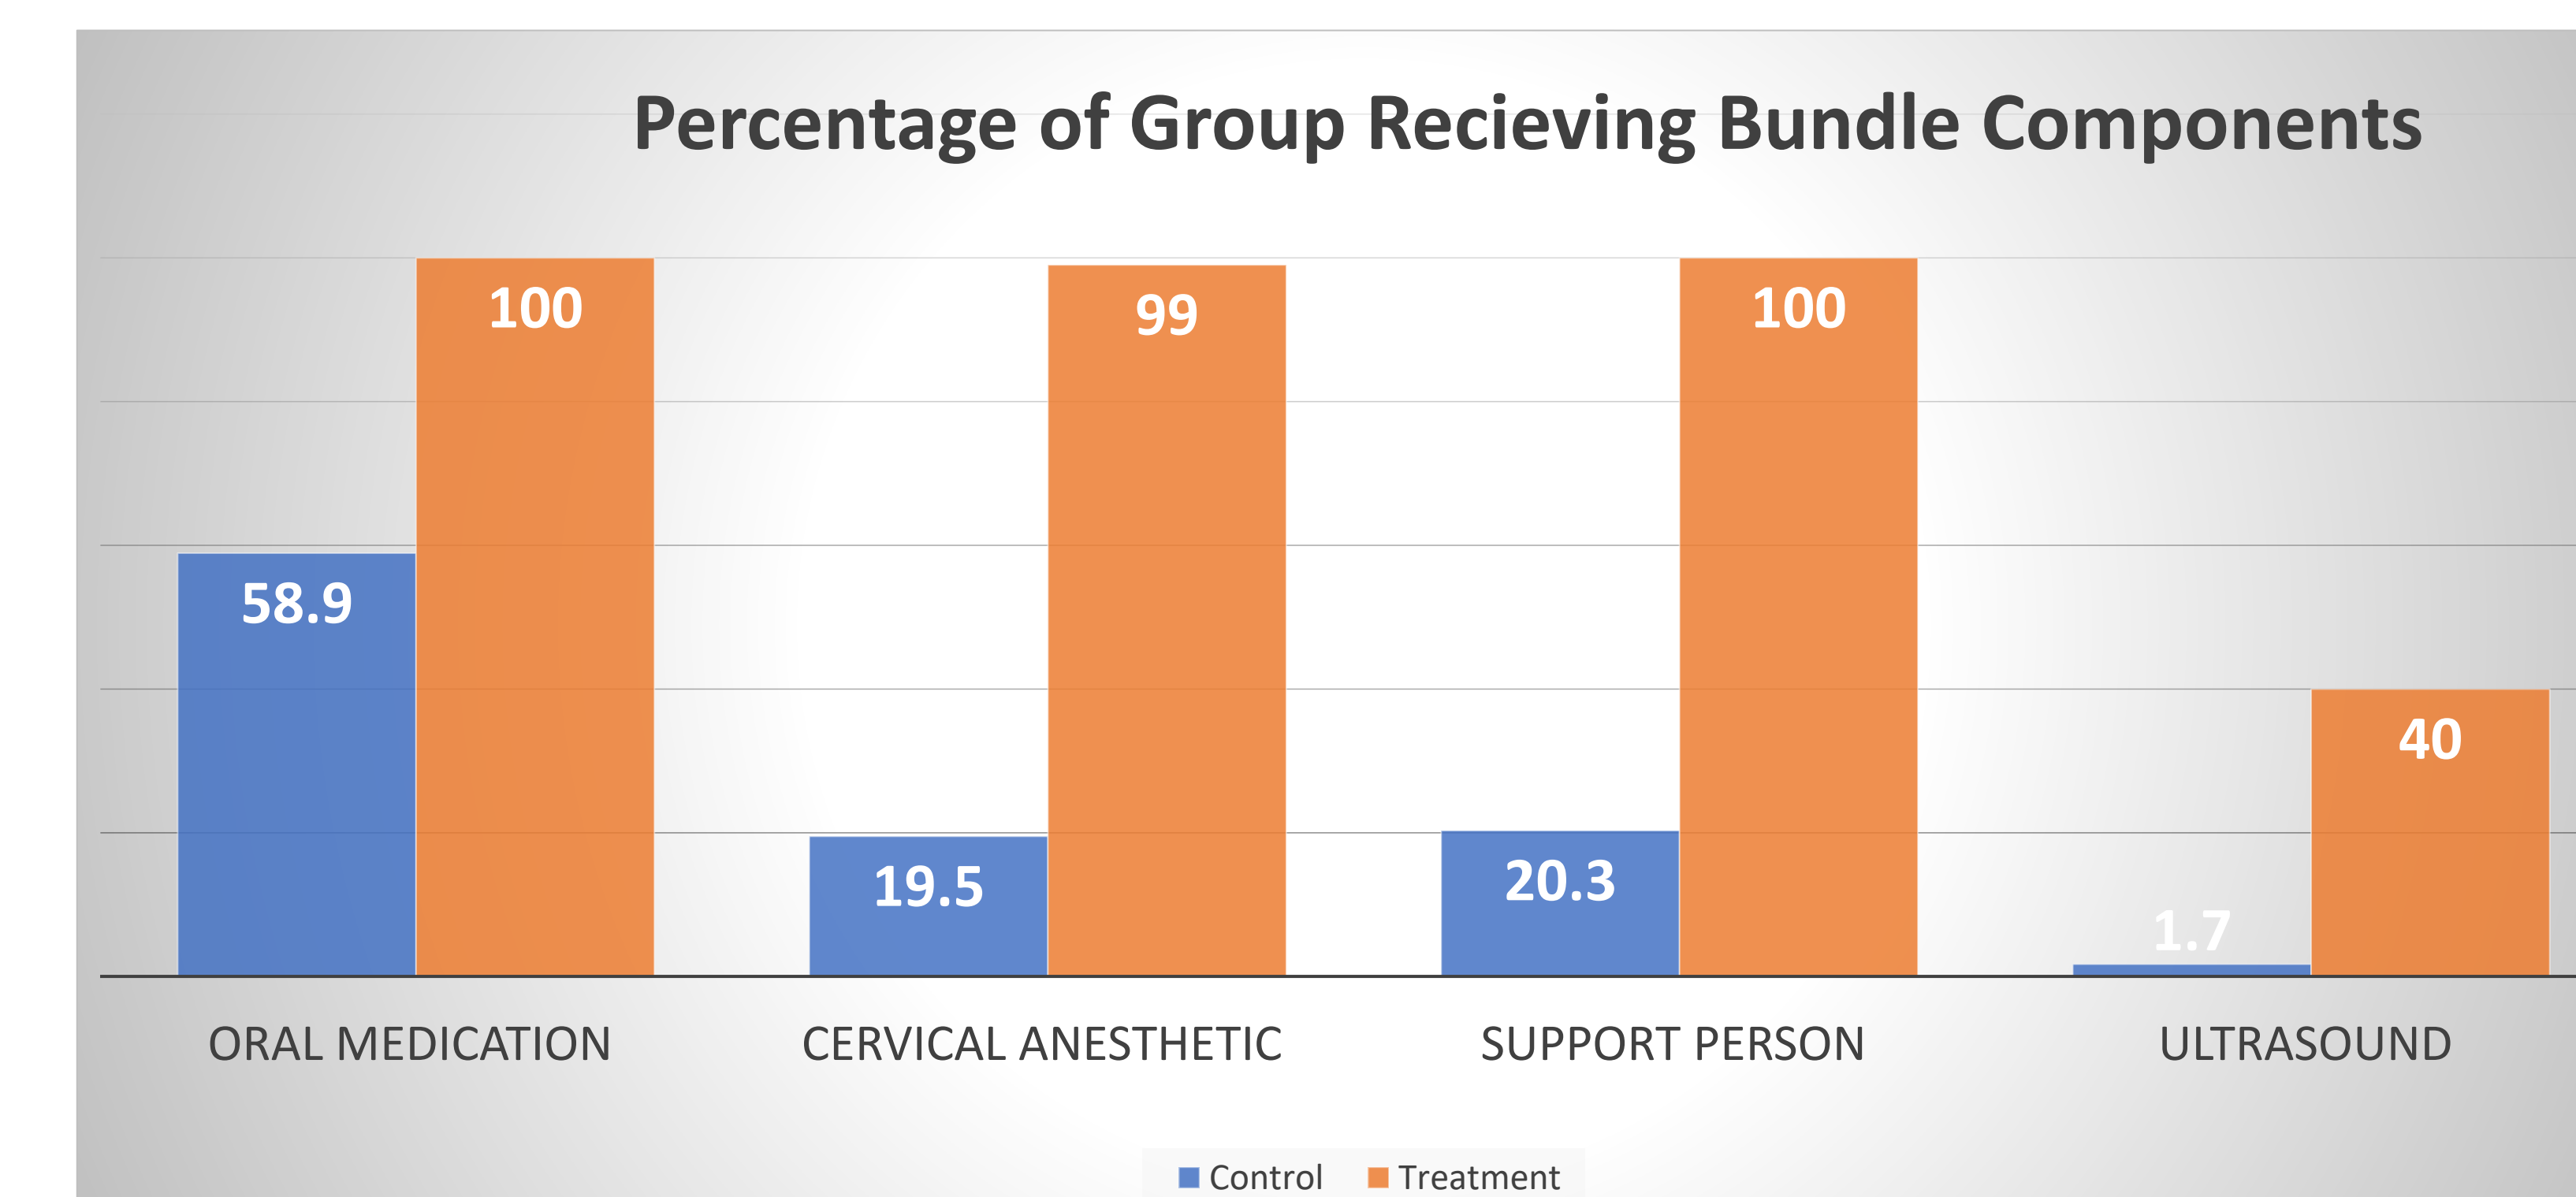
Pain management in the control group varied with 60% receiving some form of oral premedication and only 20% using topical anesthetic. Ultrasound was used in 40% of patients in the treatment group compared to <2% in the standard practice cohort
